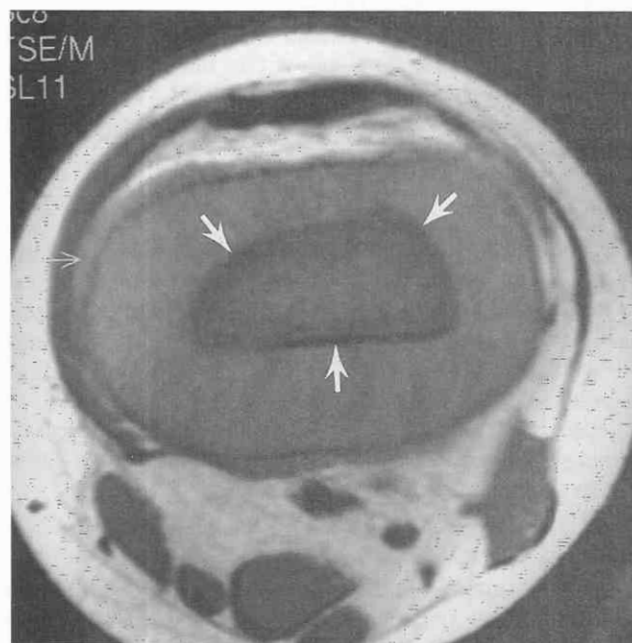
Focal distal left femoral mass due to acute lymphocytic leukemia in a 4-year-old girl. The patient initially presented with distal thigh pain and was thought to have a primary bone neoplasm of the distal femur. Axial T1-weighted image (TR = 689 msec, TE = 13 msec) shows a circumferential soft tissue mass encasing the distal femur. The underlying femoral cortex is nearly absent (arrows). Lesser abnormality was present within the other metaphyses of both knees. Plain films showed destructive changes in the distal left femur with characteristic leukemic lucent bands in the other metaphyses.
